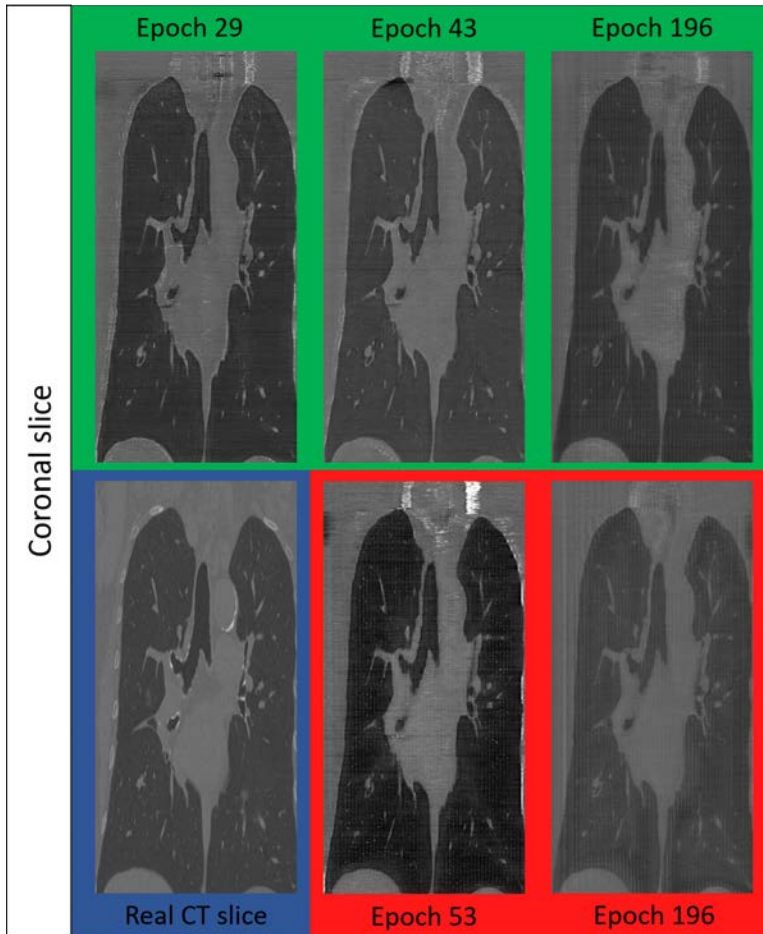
Augmented coronal CT-scans slices for Pareto and non-Pareto epochs.
